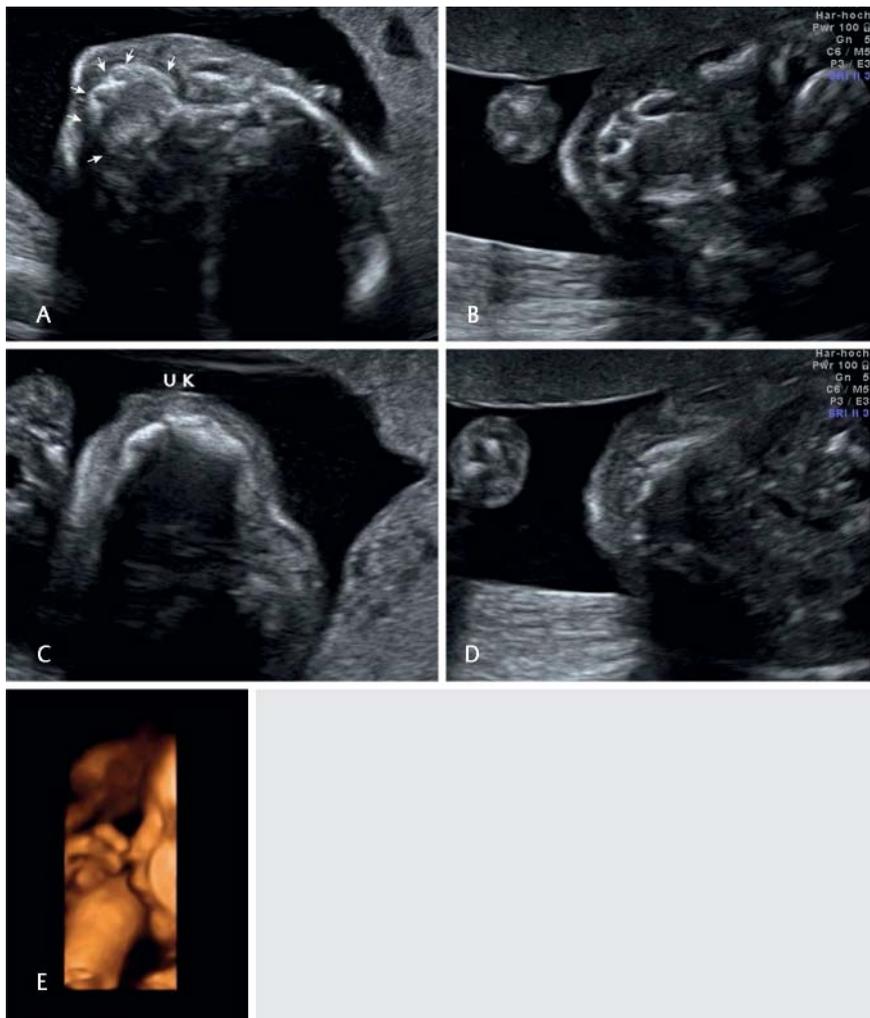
Prenatal tooth germ sonography in the 22nd week of gestation. A upper jaw of fetus M1 with XLHED showing only two dental alveoli (round hypoechoic areas with central white spots); B upper jaw of a healthy control fetus; C mandible of fetus M1 without any dental alveoli; D mandible of a healthy control fetus; E mandibular hypoplasia of fetus M1 in the three-dimensional image.
